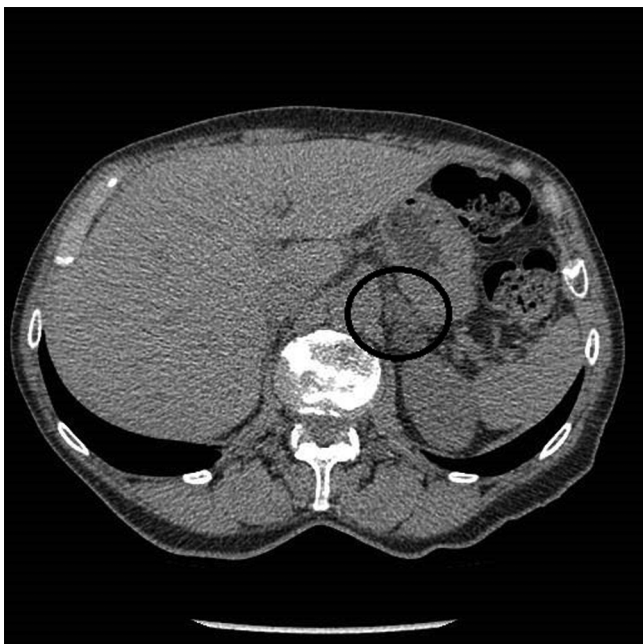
CT image of left 1.8 cm adrenal nodule with an average attenuation of 2.6 Hounsfield units.
